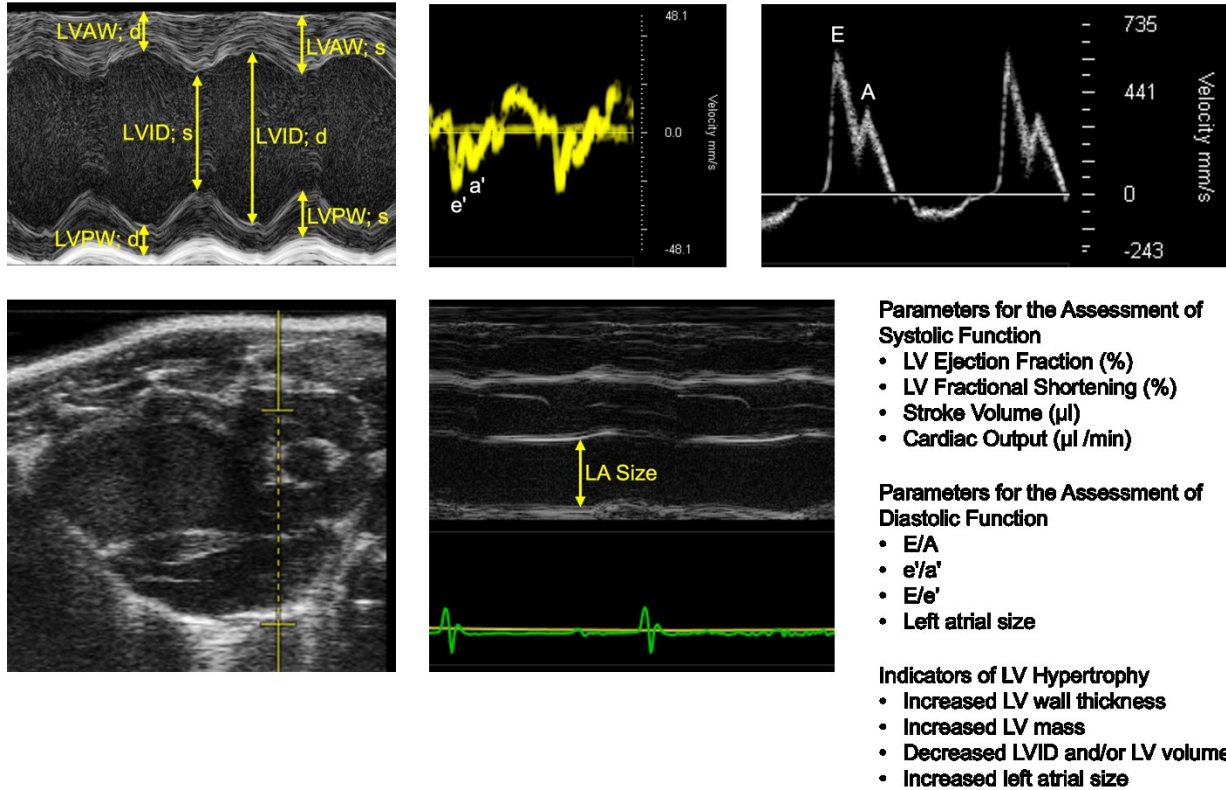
Evaluation of cardiac structure and function utilizing echocardiography. Upper panel from left to right: parasternal short axis view in M-mode, mitral annular velocity obtained by tissue Doppler imaging in the parasternal short axis view, mitral valve inflow obtained by pulsed wave Doppler imaging in the apical four chamber view. Lower panel from left to right: parasternal long axis view in B-mode with the position for the measurement of anteroposterior left atrial diameter indicated, parasternal long axis view in M-mode. LV, left ventricle; LVAW, left ventricular anterior wall; LVPW, left ventricular posterior wall; LVID, left ventricular internal diameter; s, systole; d, diastole; e', early diastolic mitral annular velocity; a', late diastolic mitral annular velocity; E, mitral peak early diastolic filling velocity; A, mitral peak late diastolic filling velocity; LA, left atrium. LA size is represented by maximal anteroposterior left atrial diameter.
